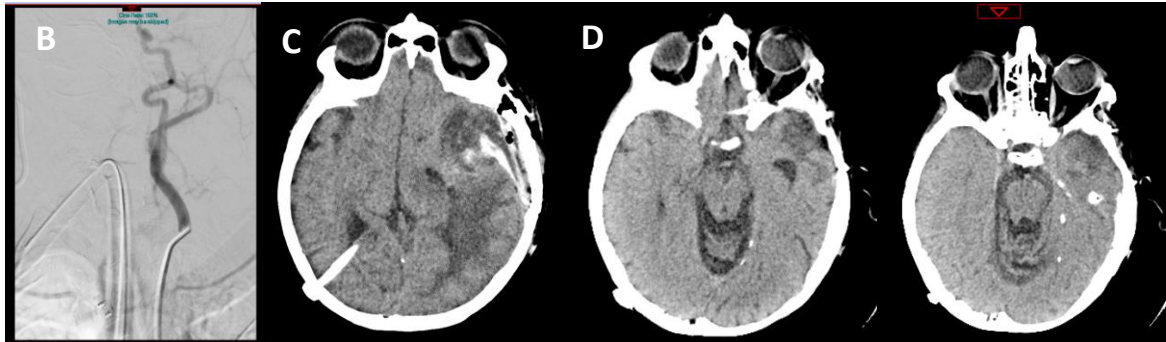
Axial CT angiography (CTA) scan demonstrating (A) Large, vascular sphenoid wing meningioma. The patient underwent successful pre-operative embolisation of the left common carotid artery (B). Pathology revealed a WHO grade 1 meningioma; post-operative axial non-contrast CT scan showing a small collection of blood in the resected area (C), and follow up CT scan 6 months after surgery demonstrating bleeding resolution (D).
